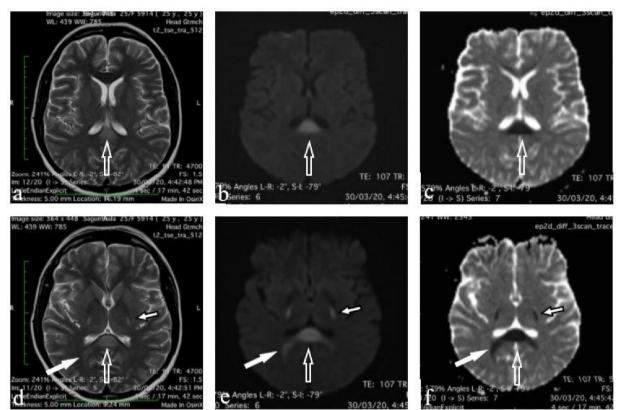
Magnetic resonance imaging of another patient showing axial sections of T2-weighted (a, d), DWI (b, e) and corresponding ADC mapping (c, f) which reveals T2 hyperintensity in splenium of corpus callosum (open arrow) extending into forceps major (solid arrow) and bilateral posterior limb of internal capsule (small solid arrow) and showed restricted diffusion appearing bright on diffusion images and hypointense on ADC.
